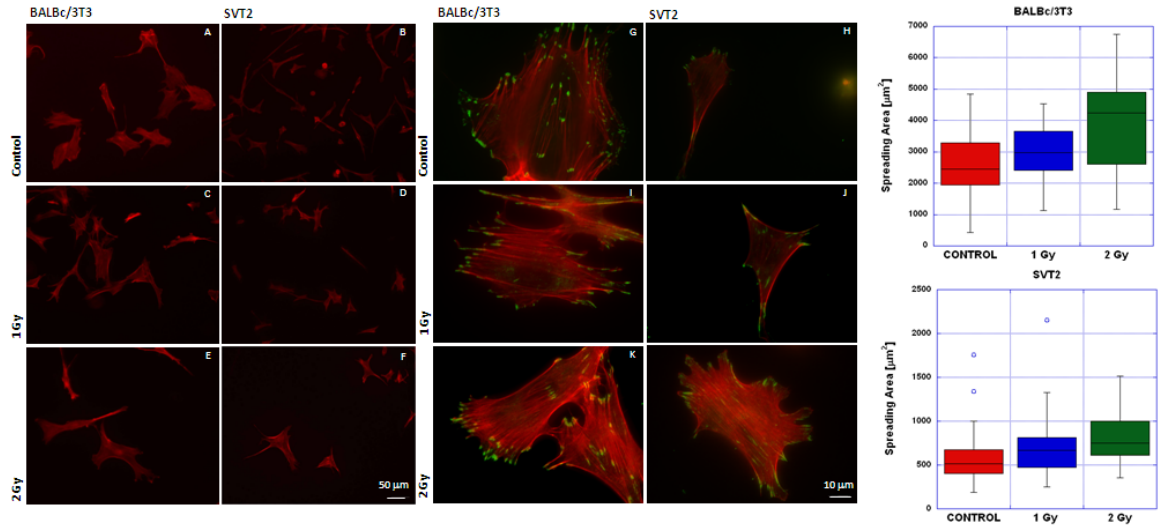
X-rays with dose of 2 Gy seemed to induce an increase in spreading and structuring of cytoskeleton at 24 h after irradiation. The increase in mean spreading area we measured when the two cell lines were irradiated with lower dose was not resulted significantly different.
